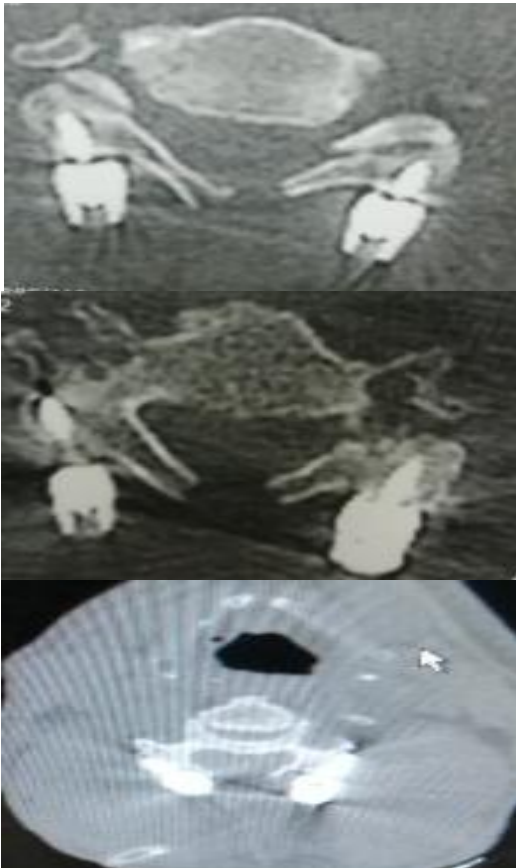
Postoperative CT cervical spine axial views at different levels showing lateral mass screws trajectory along with laminectomy to decompress cervical spine in different patients.
